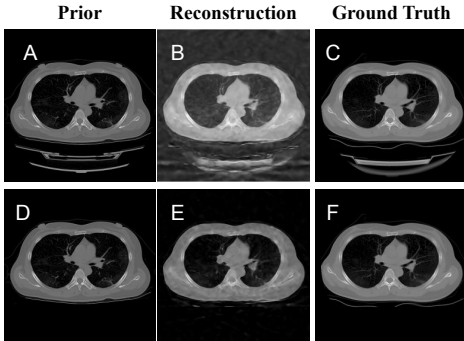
Comparison of 2D CT reconstruction with the device bed in the first row and without the device bed in the second row.
